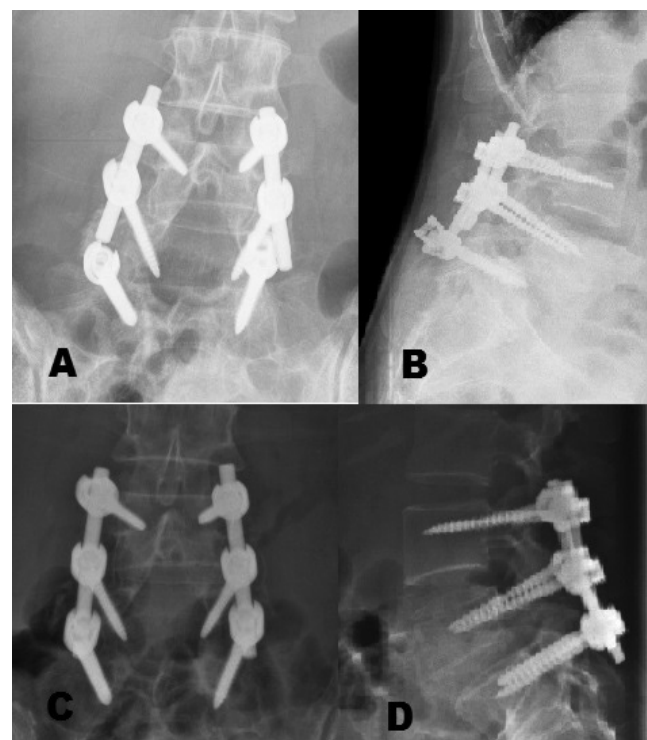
A and B; bilateral rod pull out owing to non-fusion after lifted a load of 25 kg (anteroposterior X-ray and lateral X-ray), C and D; anteroposterior and lateral X-ray after revision surgery
